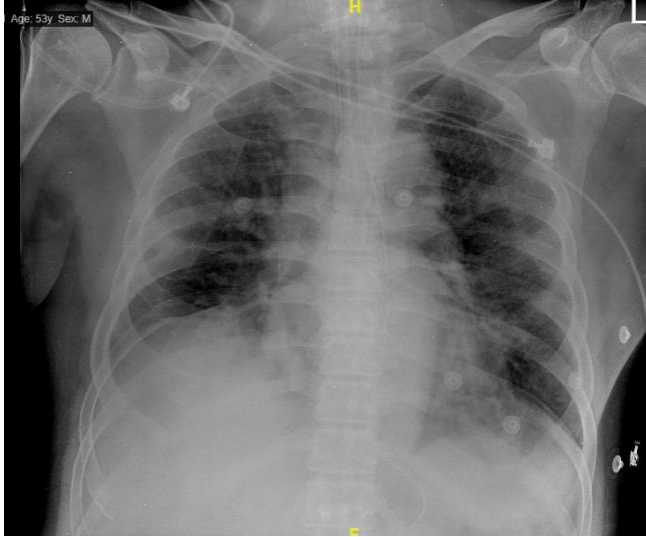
Chest x-ray on April 1st
